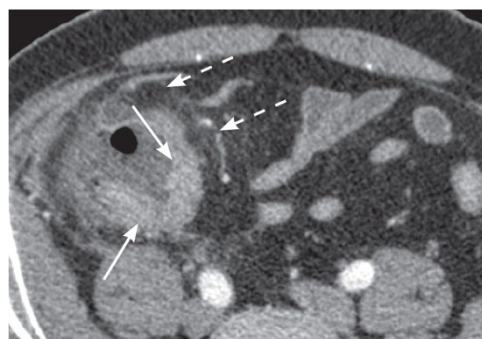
Patient Z., 70 years old. Contrast-enhanced computed tomography of the abdomen, portal phase. Axial slice. Posteromedial location of the edematous and tortuous appendix (white arrows). The presence of a periappendicular inhomogeneous masses with unevenly thickened contrasting walls, liquid contents and gas bubbles (dashed arrows)
